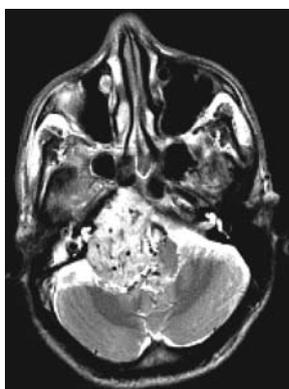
Axial cut, T2 weighted MRI internal auditory canal level.
